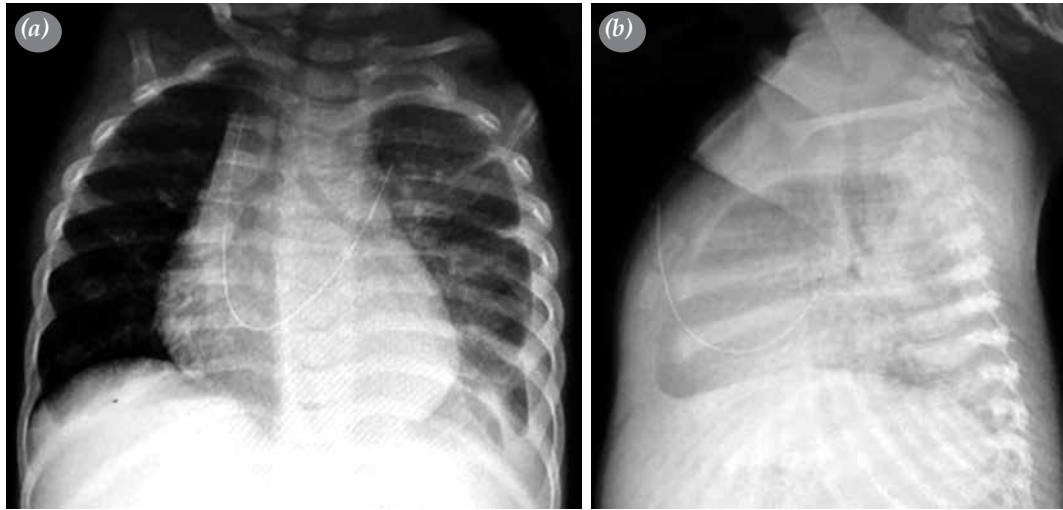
(a, b) Chest X-ray showing retained guidewire fragment in the right internal jugular vein, heart and reaching out to thoracic cavity and subcutaneous tissue.
